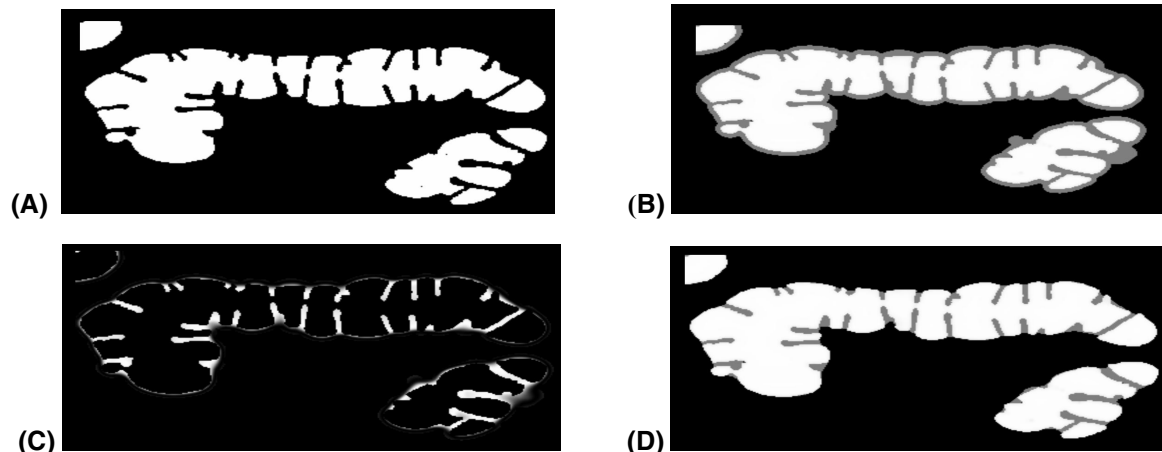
Stages in processing of dataset 1. A single CT colonography slice through the transverse colon is shown. (A) Segmented colon. (B) Diffusion map. (C) Fuzzy C-means clustering. (D) Label filtering and thresholding of fuzzy membership values.
